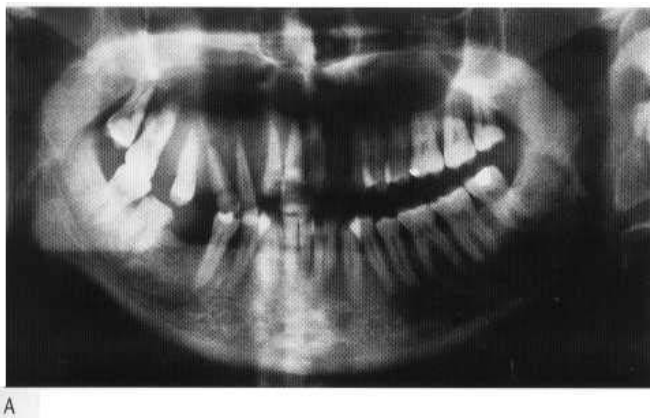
(A) Orthopantomogram (OPG). There is abnormal bony texture and destruction of the right side of the maxilla. (B) OPG shows bony destruction of the right side of the maxilla with an abnormal opacity within the right maxillary antrum. This was due to a squamous cell carcinoma with adjacent bone invasion. (C) Occipitomental (OM) view demonstrates an opacity of the right maxillary antrum with destruction of the lateral wall of the maxillary antrum. An abnormal opacity is also seen within the nasal cavity.
